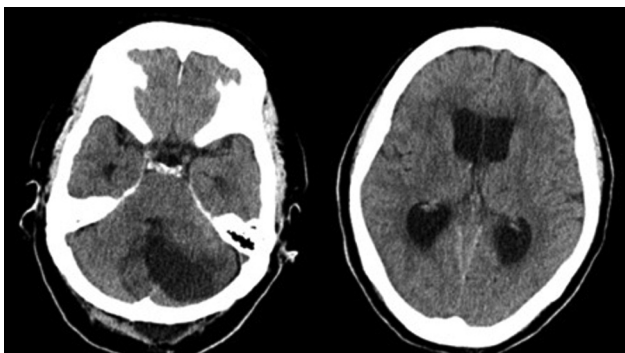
Computed tomogram images taken on the 8th day after surgery showed the cyst enlargement and worsening hydrocephalus.
